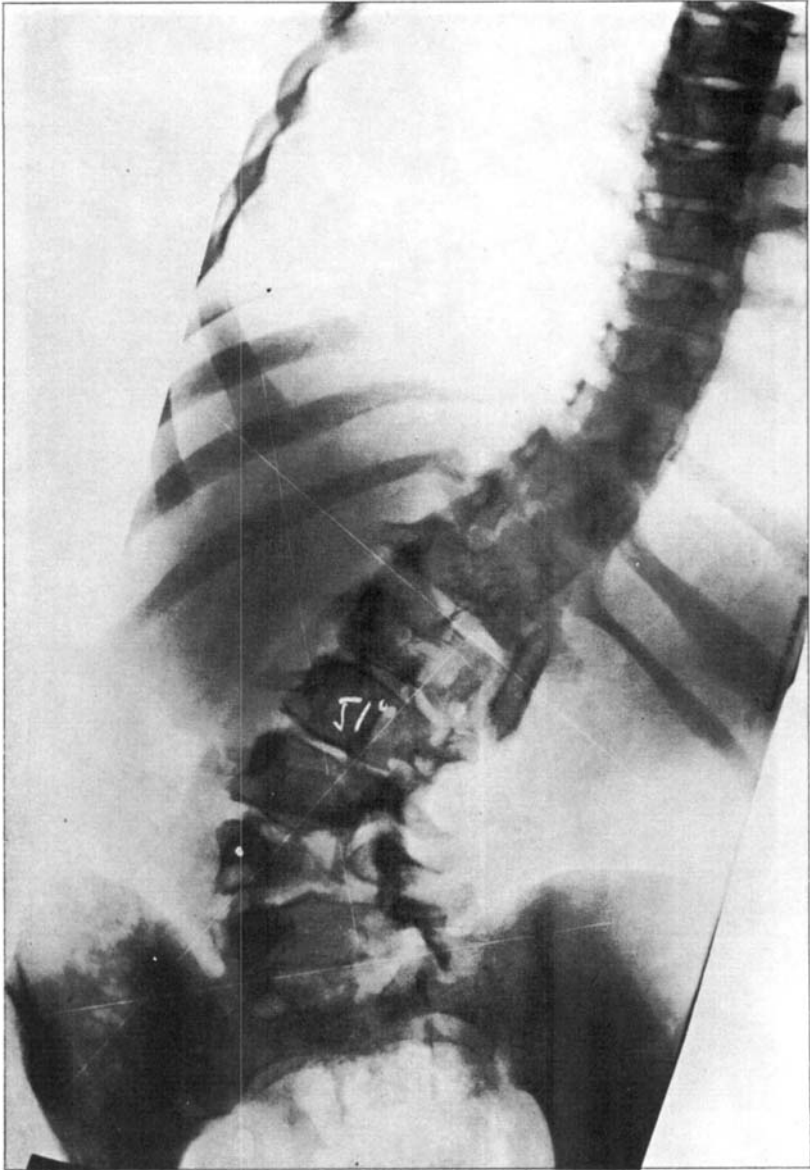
Age ten years. Marked lumbar scoliosis. Severe deviation of the trunk. Radiograph taken in a recumbent position.
